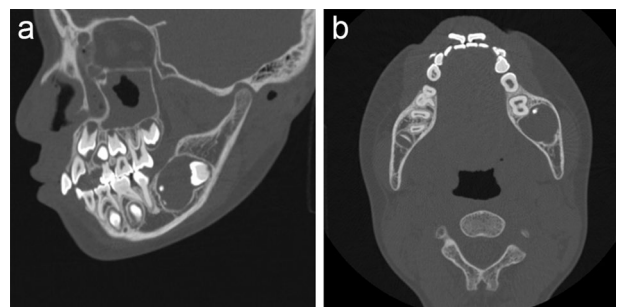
CT examination. a Sagittal section. A unilocular low attenuation area measuring approximately $24 \times 19 \times 26$ mm on the left side of the mandible including the crown of the mandibular left second molar. Multiple calcified bodies are present within the lesion, one of which had a CT number of approximately 2200 HU. b Axial section. Buccolingual bony expansion and cortical bone thinning caused by the lesion
